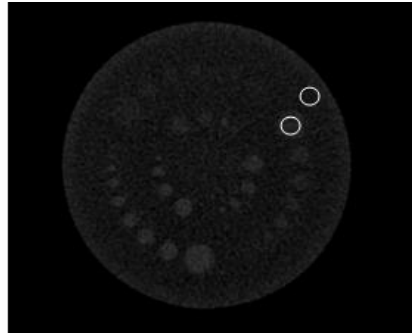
8 Measurement the CT number of low contrast object and background
